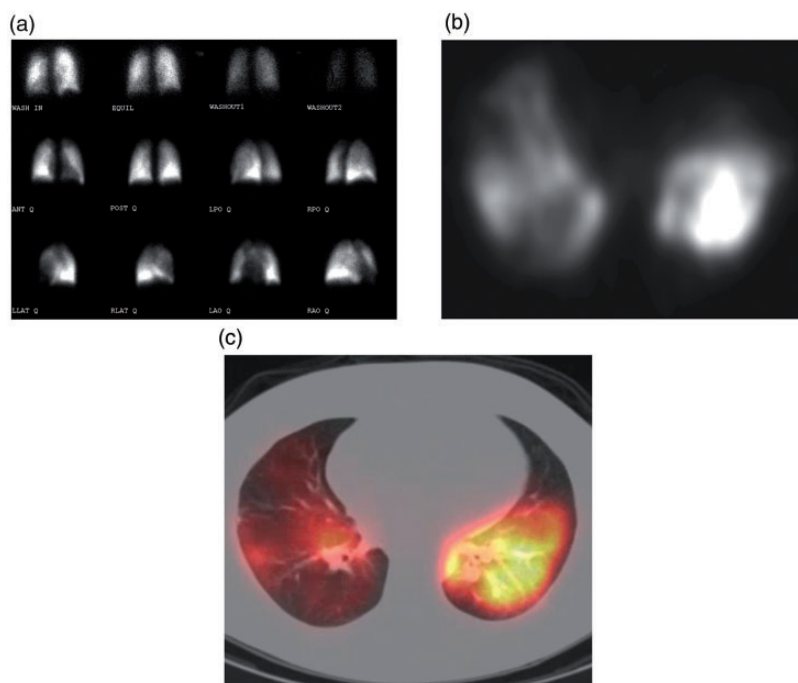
V/Q scintigraphy techniques. (a) A planar V/Q scan performed in various planes on a gamma camera yields two-dimensional projections of complex three-dimensional (3-D) anatomy, akin to a radiograph. (b) A SPECT camera is a tomographic version of the gamma camera and can obtain slices through the body allowing for three-dimensional detail. (c) The data from the SPECT can be fused to a computed tomography scan to simultaneously visualize anatomy and physiology. Source: Image supplied by the authors.
